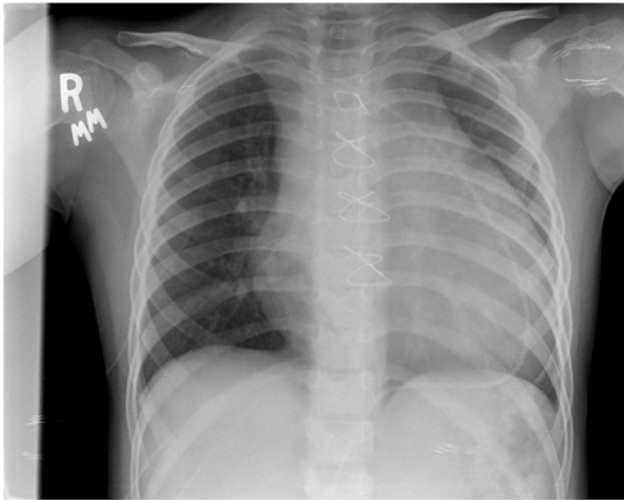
Chest X-ray of the patient showing a cardiothoracic ratio of 0.71 on post-op day 6.
